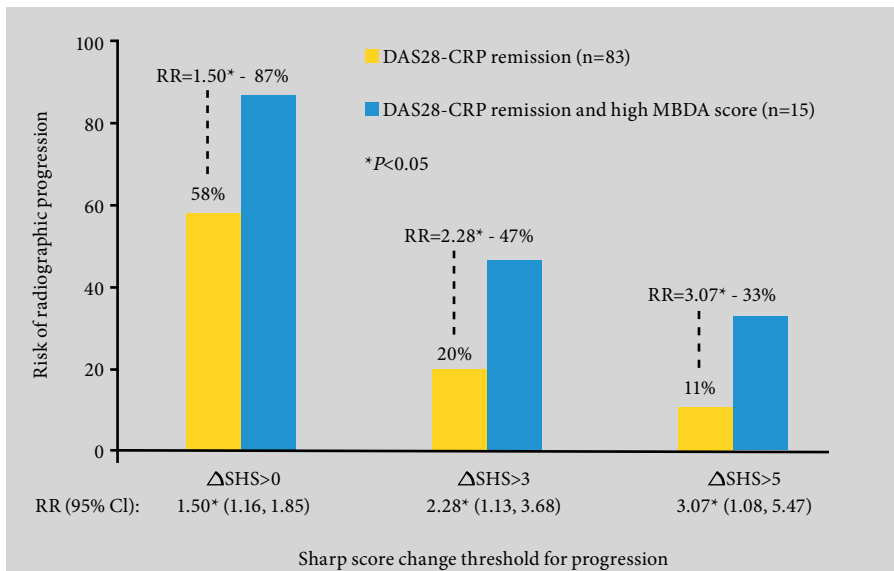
A high multi-biomarker disease activity score for subjects in 28-joint disease activity and C-reactive protein score remission indicates increased risk of radiographic progression. CI, confidence interval; DAS28-CRP, 28-joint disease activity and C-reactive protein score; MBDA, multi-biomarker disease activity; RR, response rate; SHS, Sharp/van der Heijde score. Reproduced with permission from van der Helm-van Mil et al [39] ©OUP.
